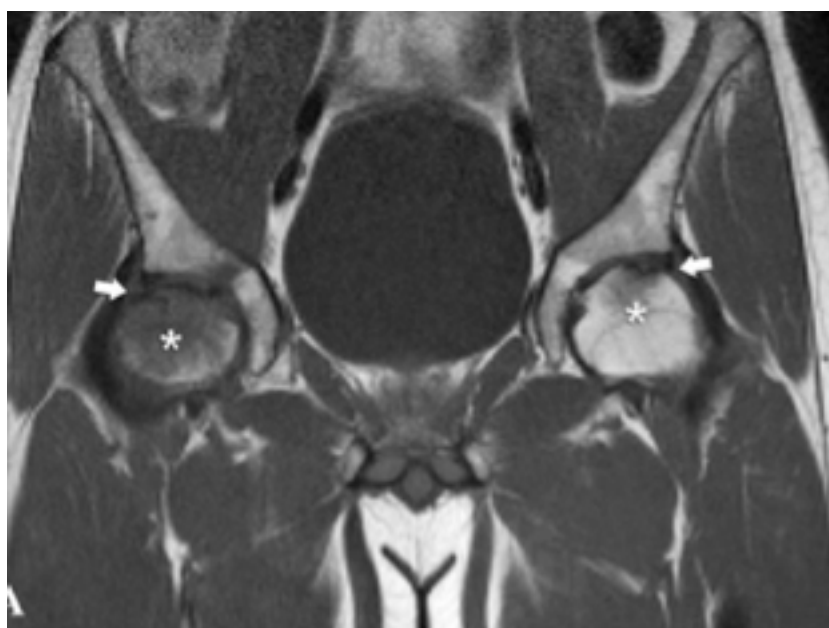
A T1 weighted MRI sequence of a pelvis with bilateral BSI.
